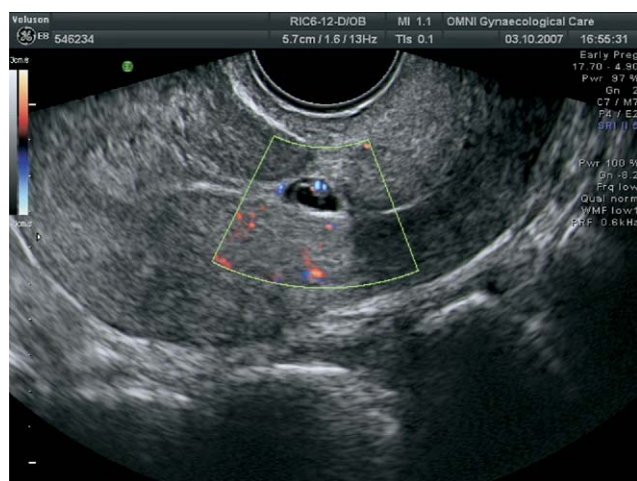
Viability of a caesarean section scar pregnancy demonstrated with color Doppler. (Color version of figure is available online.)
